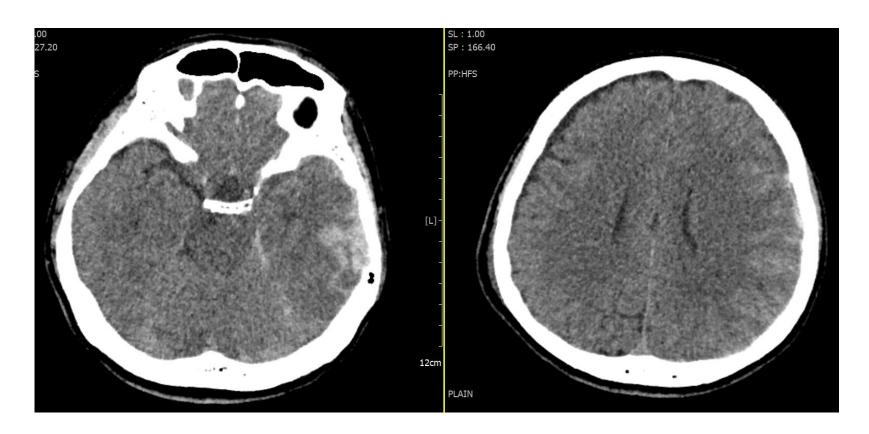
CT Brain on post trauma day 1 showed left temporal contusion bleed without any mass effect.
